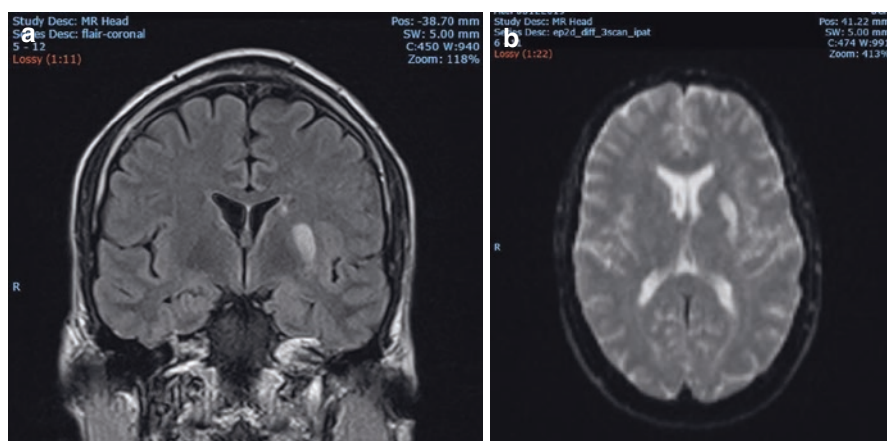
MRI scan of the brain: (a) coronal FLAIR sequence showing increased signal within the left corona radiata, and (b) diffusion weighted imaging showing restricted diffusion throughout the territory of the left middle cerebral artery
